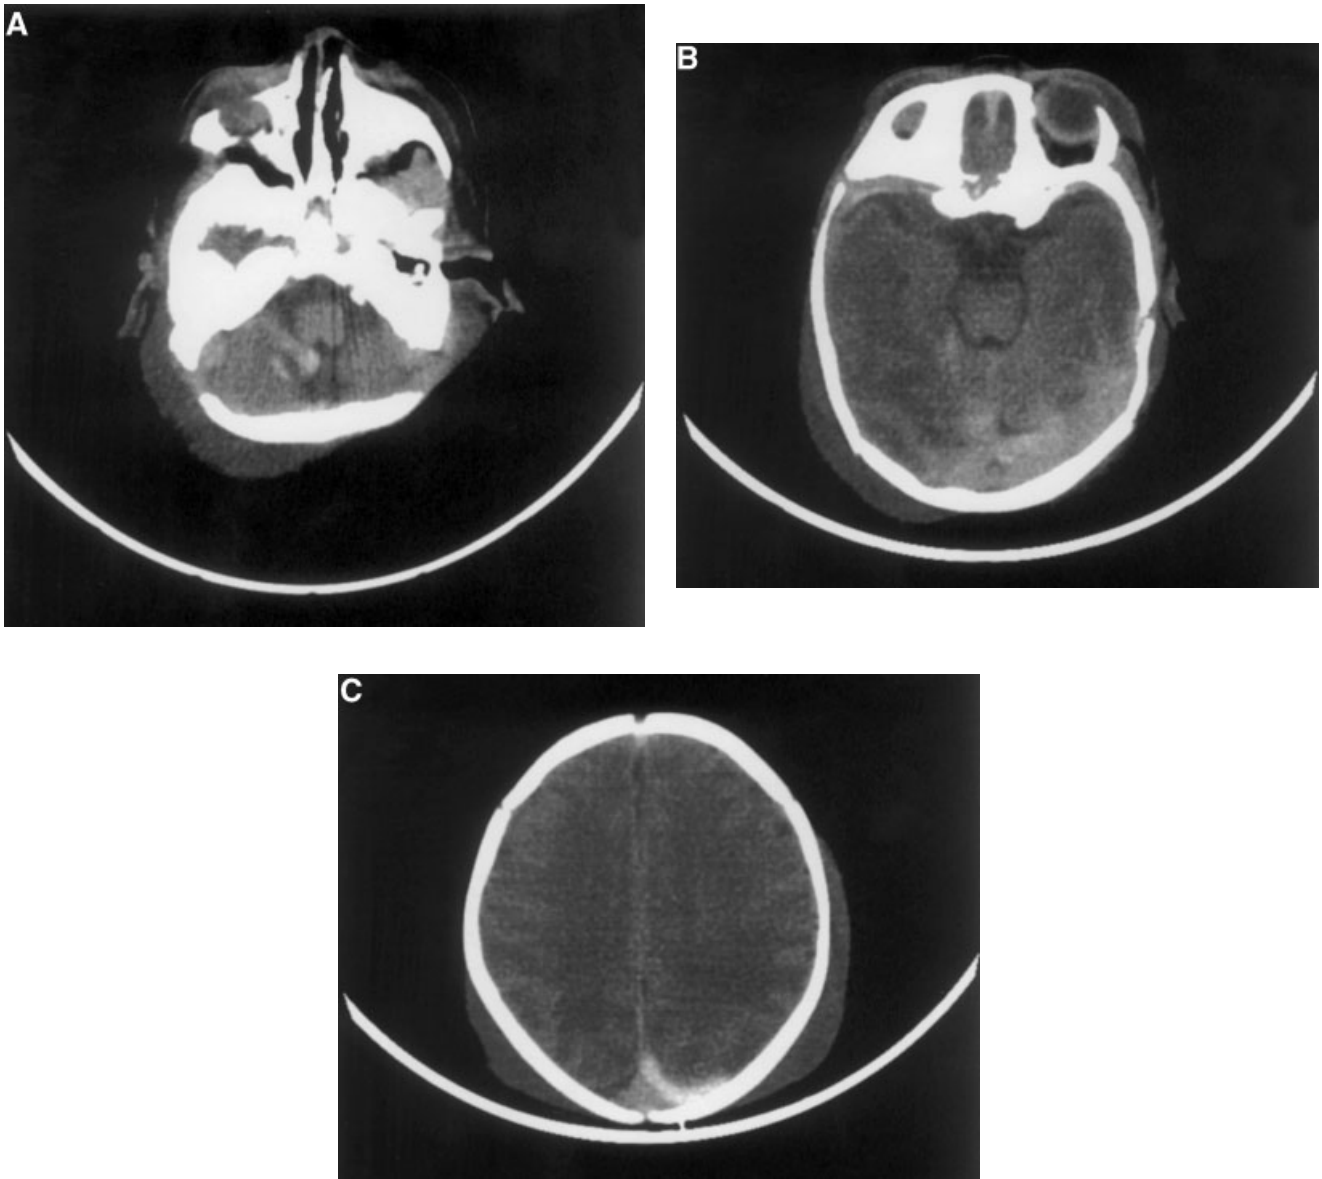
(Hospital Day 4). CT of the brain without contrast. Increase in subdural hemorrhage with extension along the posterior interhemispheric fissure (A,B). Increased parenchymal edema (C).
